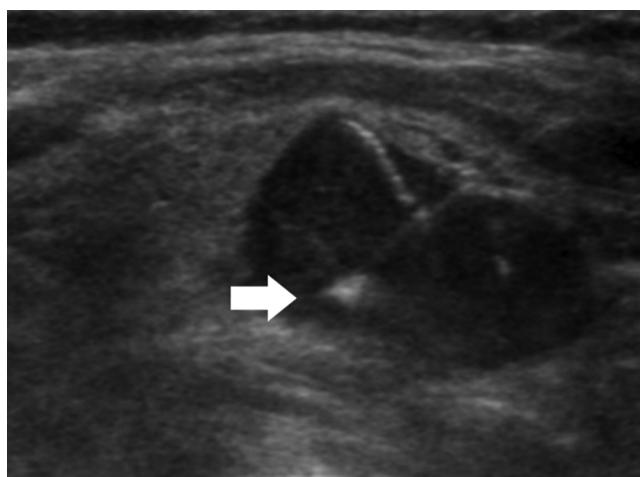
Transverse ultrasound image of the right thyroid gland in a patient with chronic renal failure and secondary hyperparathyroidism showing a round hypoechoic parathyroid nodule (1 cm \times 2.1 cm). The echogenic focus (arrow) at the needle tip represents ethanol injected for ablation. The parathyroid hormone before and after percutaneous ethanol injection therapy was 2542 pg/mL and 1665 pg/mL, respectively
